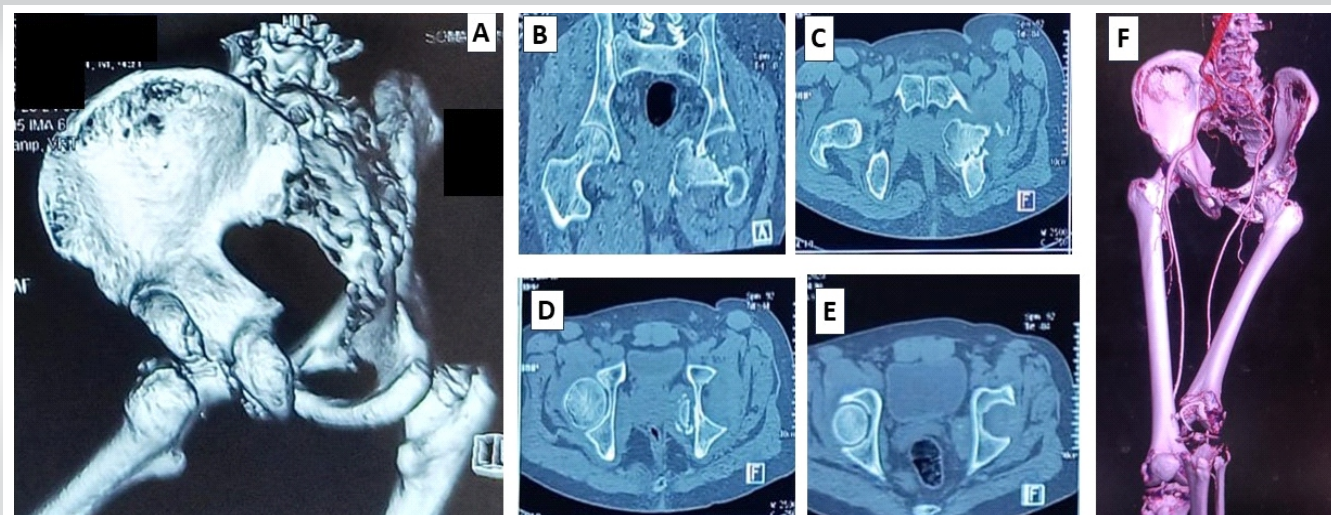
(A) #D reconstruction CT showing an anterior; (B-D) 2D CT showing an impacted obturator type dislocation without wall fracture; (E) the CT angiography displaying the vessels from the planned neck osteotomy site. (F) CT: Computed tomography.
